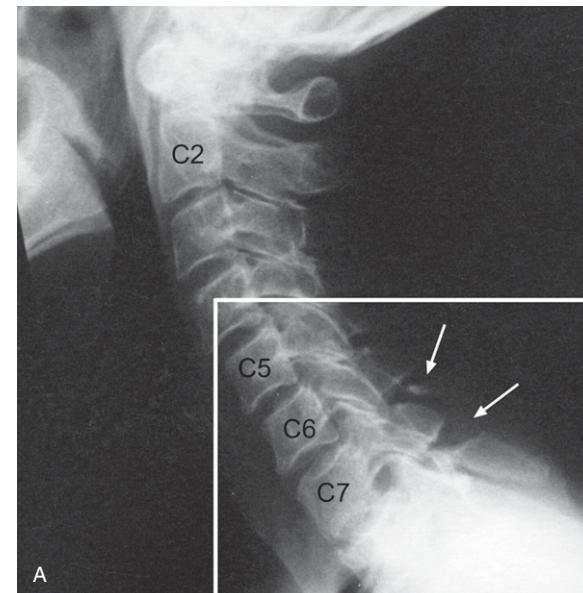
(A) Cervical spine lateral plain X-ray image. Note (i) loss of the normal cervical spine contour, and (ii) the fractures of the C6 and C7 spinous processes (white arrows). The area below the white line is shown enlarged in (B).
